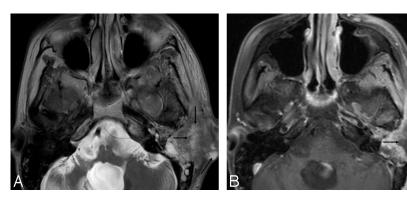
Axial T2-weighted (*A*) and postcontrast T1-weighted (*B*) images in a 40-year-old female patient demonstrate a destructive left skull base pathology with heterogenous hyperintensity and cystic areas on T2-weighted images (*black arrows*) and nonenhancing portions on the postcontrast images (*black arrows*). This was a biopsy-proven adenosquamous cell carcinoma with an increased ADC value averaging $1.649 \times 10^{-3} \text{ mm}^2/\text{s}$, probably due to the necrotic areas within the tumor.
